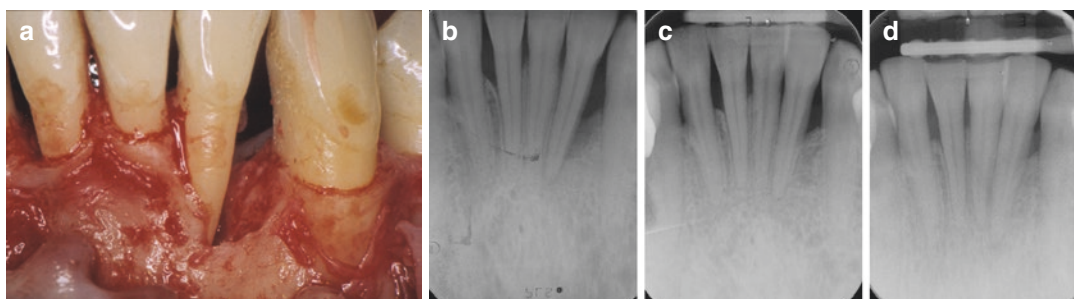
(a, b) Clinical and radiographic (respectively) aspect of lower anterior teeth shows generalized loss of periodontal support, especially on distal aspect of lateral left incisor. (c) Radiograph taken 1 year following reconstructive periodontal treatment with use of enamel matrix proteins derivative, enhanced periodontal support may be
